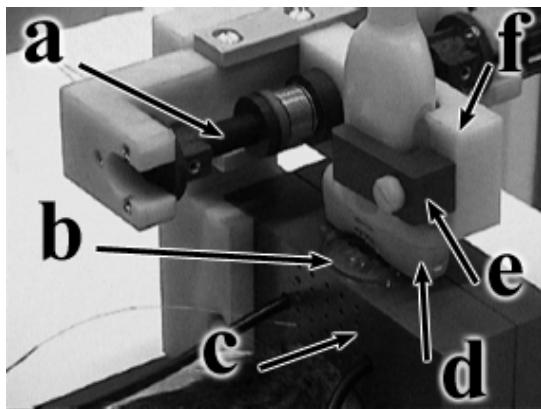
The 3D positioning device for an ultrasound probe: screw rail (a), contact gel (b), applicator (c), ultrasound probe (d), pressing arm (e), probe holder (f)
